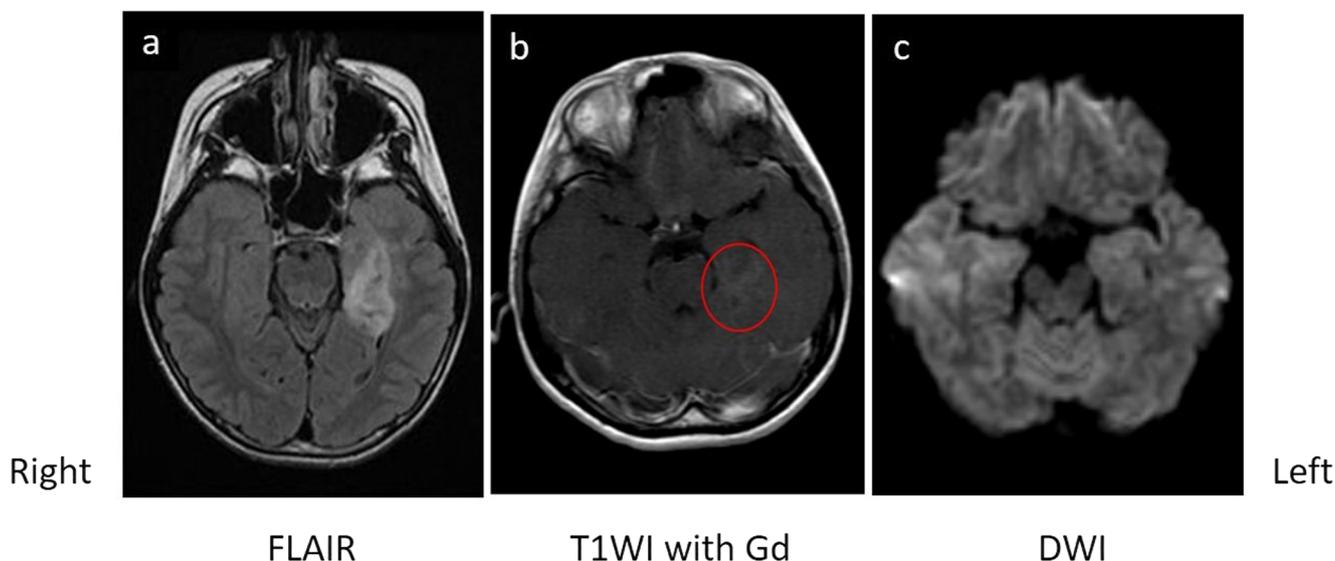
The first MRI study at 9 years 8 months old. a Fluid-attenuated inversion recovery (FLAIR) MRI (left side) revealed a high-intensity cortico-subcortical area in the left temporo-occipital area and involved the medial temporal region and the hippocampus. b T1-weighted
